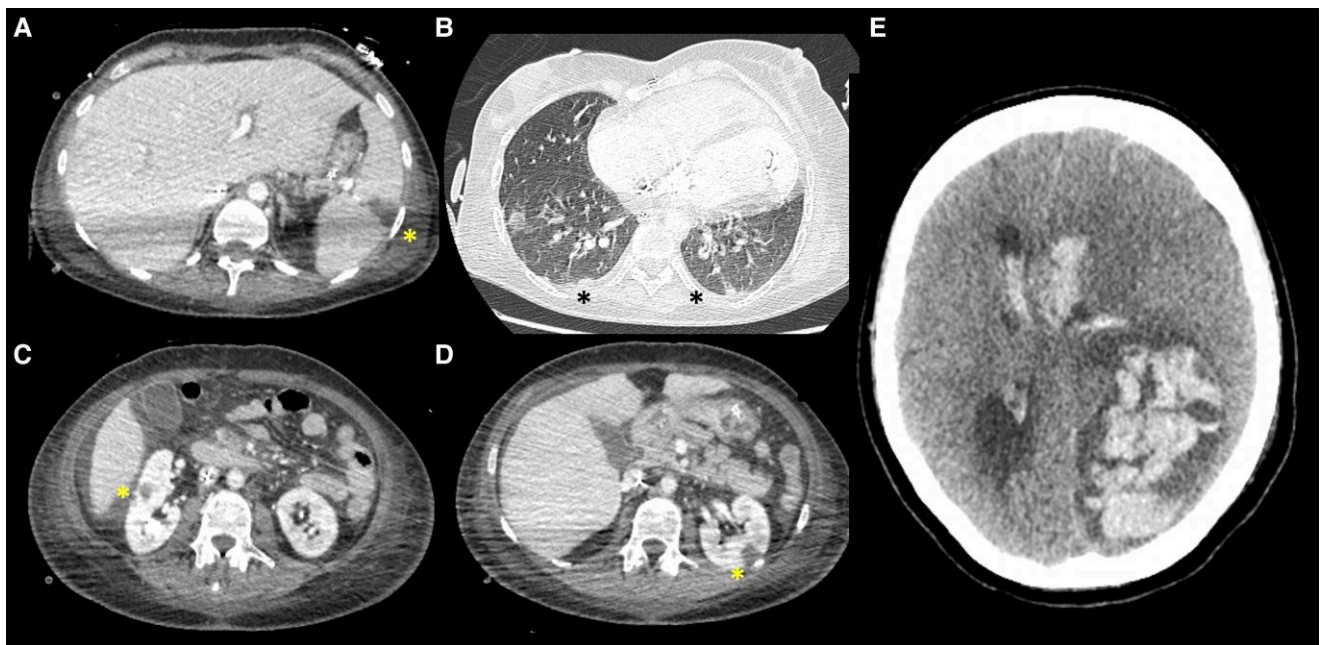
Total-body computed tomography demonstrating multiorgan embolization: hypodense ischaemic areas in the spleen (A), bilateral pleural-based peripheral thickenings with triangular morphology (B), ischaemic areas in both kidneys (C and D), and a large haemorrhage involving the left fronto-parieto-occipital region, with intraventricular extension into both frontal horns of lateral ventricles, with effacement of cortical sulci and midline shift of 11 mm (E). CT, computed tomography; asterisks, ischemic areas.
